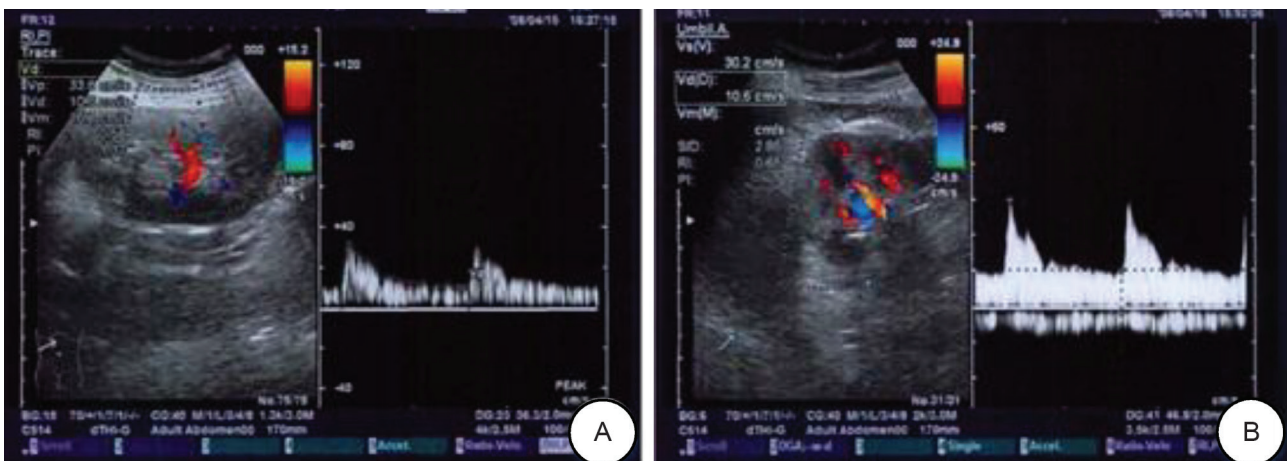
Color Doppler Ultrasound Images of the Kidneys (a: Control Group, b: Study Group)
